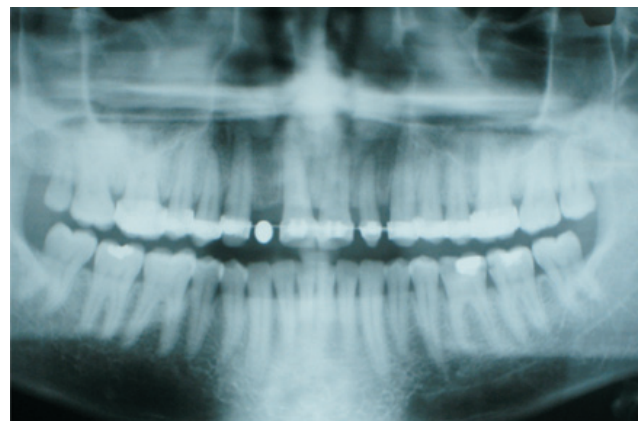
A preoperative orthopantomograph taken to ascertain the height of the available bone for implant placement
